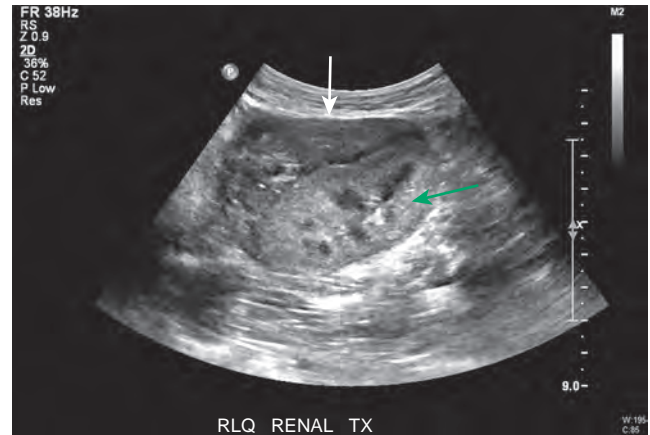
Subcapsular hematoma. Bleeding under the capsule of the kidney forms a hematoma (white arrow) which compresses the renal parenchyma (green arrow) resulting in reversal of diastolic flow on Doppler ultrasound.
